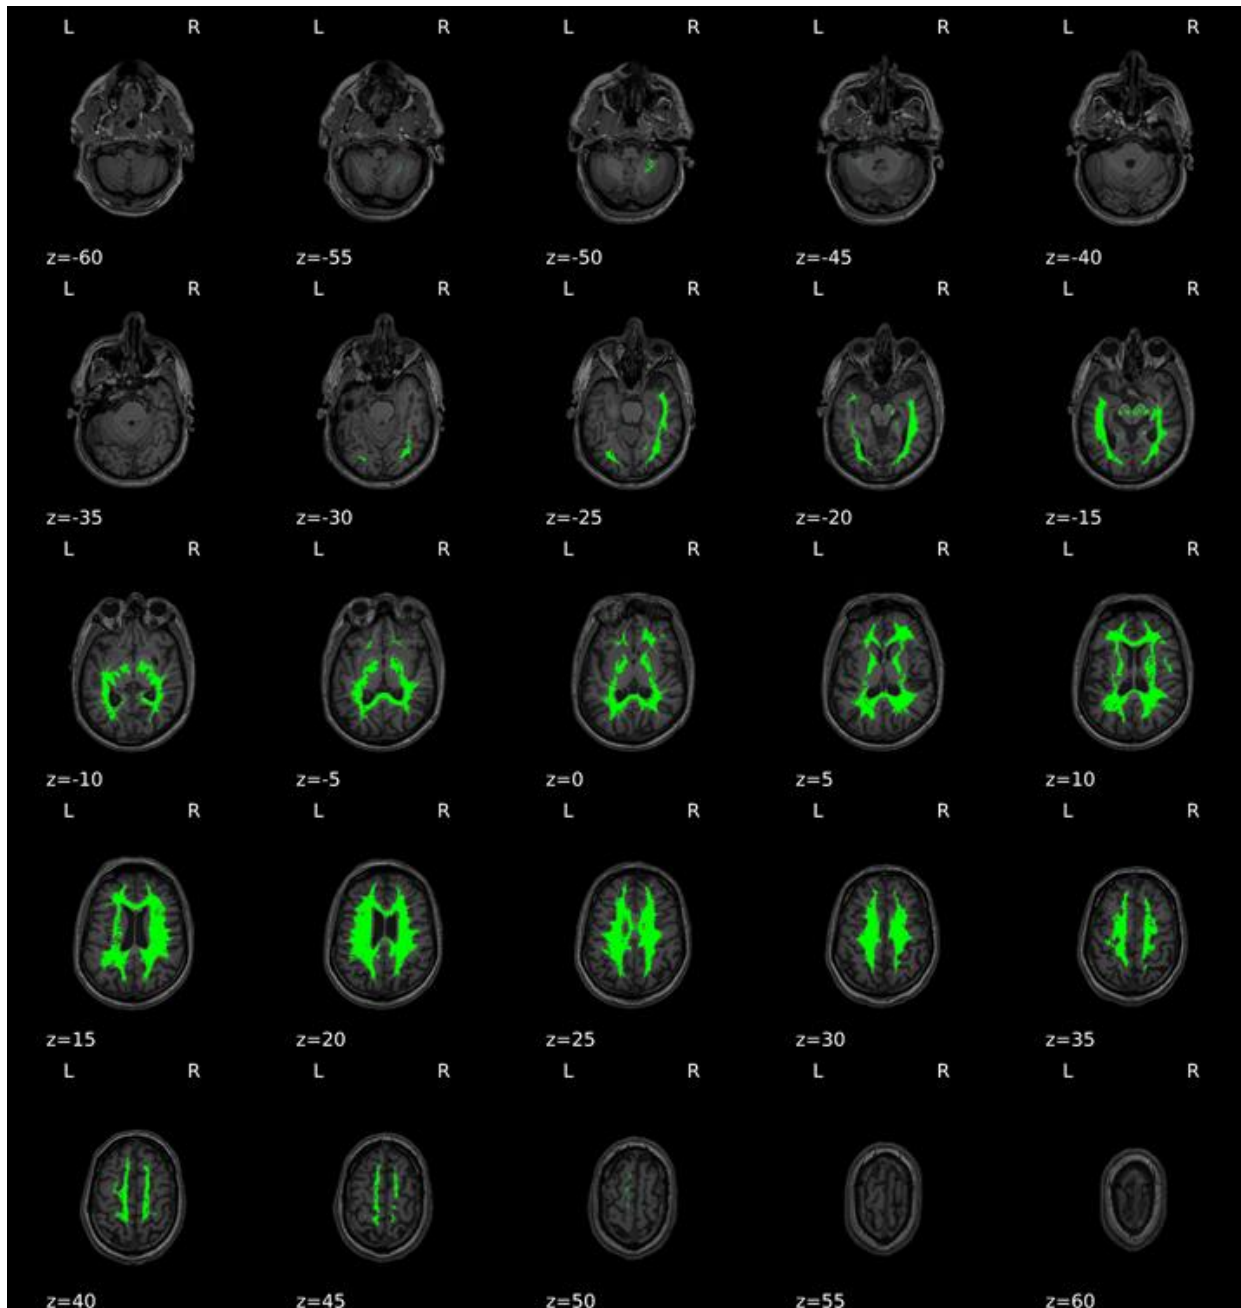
Example patient's MRI in neurological imaging convention with green overlay of generated 99.9% probability white matter mask.
